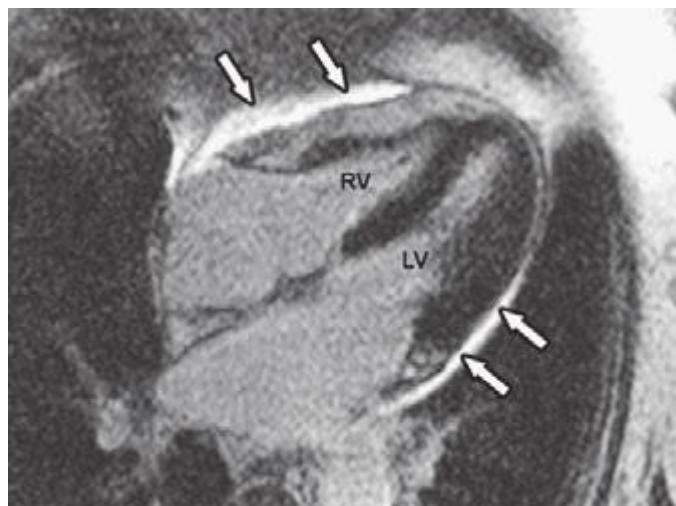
Magnetic resonance imaging in chronic constrictive pericarditis. The arrows point to a thickened pericardium, which shows late enhancement after gadolinium, characteristic of intense inflammation. LV, left ventricle; RV, right ventricle. (From RY Kwong: *Cardiovascular magnetic resonance imaging*, in RO Bonow et al [eds]: *Braunwald's Heart Disease*, 9th ed. Philadelphia: Elsevier, 2012.)
